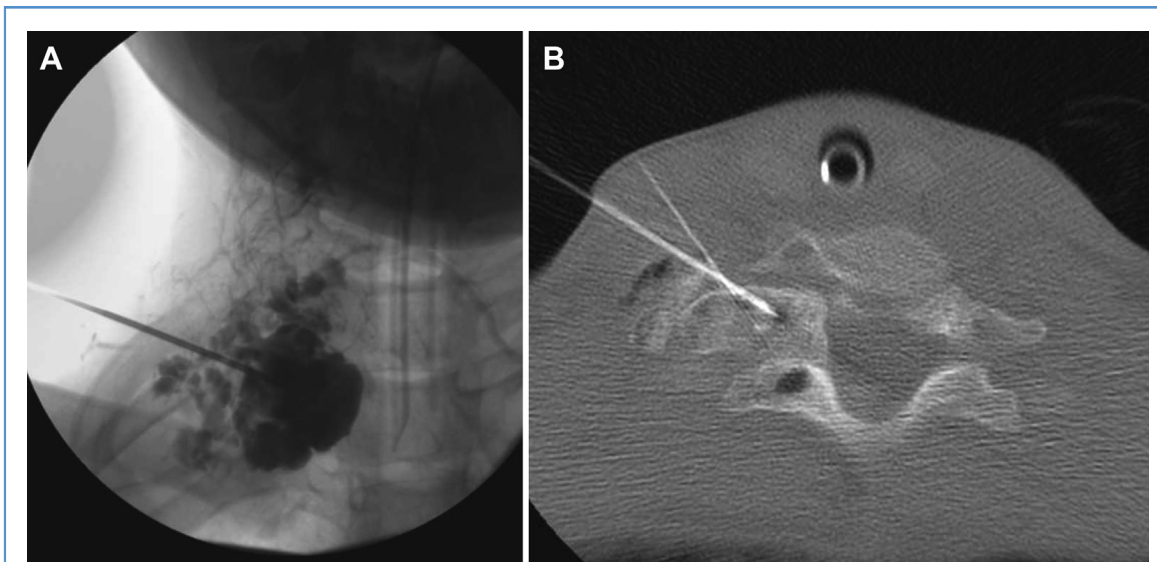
Percutaneous sclerotherapy performed initially with fluoroscopic (A) and ultrasound guidance and later with computed tomography (CT) guidance (B). During initial treatment (A), a biopsy was performed, and sclerotherapy was performed with doxycycline foam after initial contrast injections to
